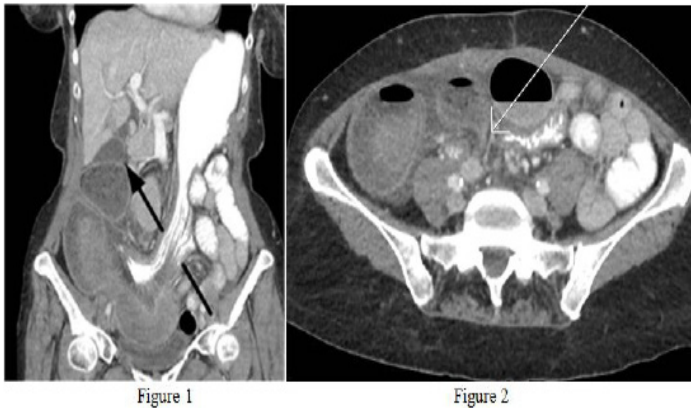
CT image showing a small bowel obstruction with herniation under the antrum and through the pars flaccida exiting above the stomach (arrow).
